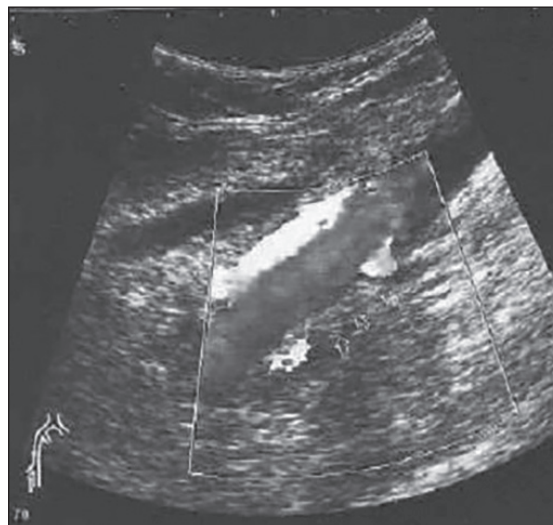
Femoral artery ultrasonography. The arrows indicate deep femoral artery with the graft.
